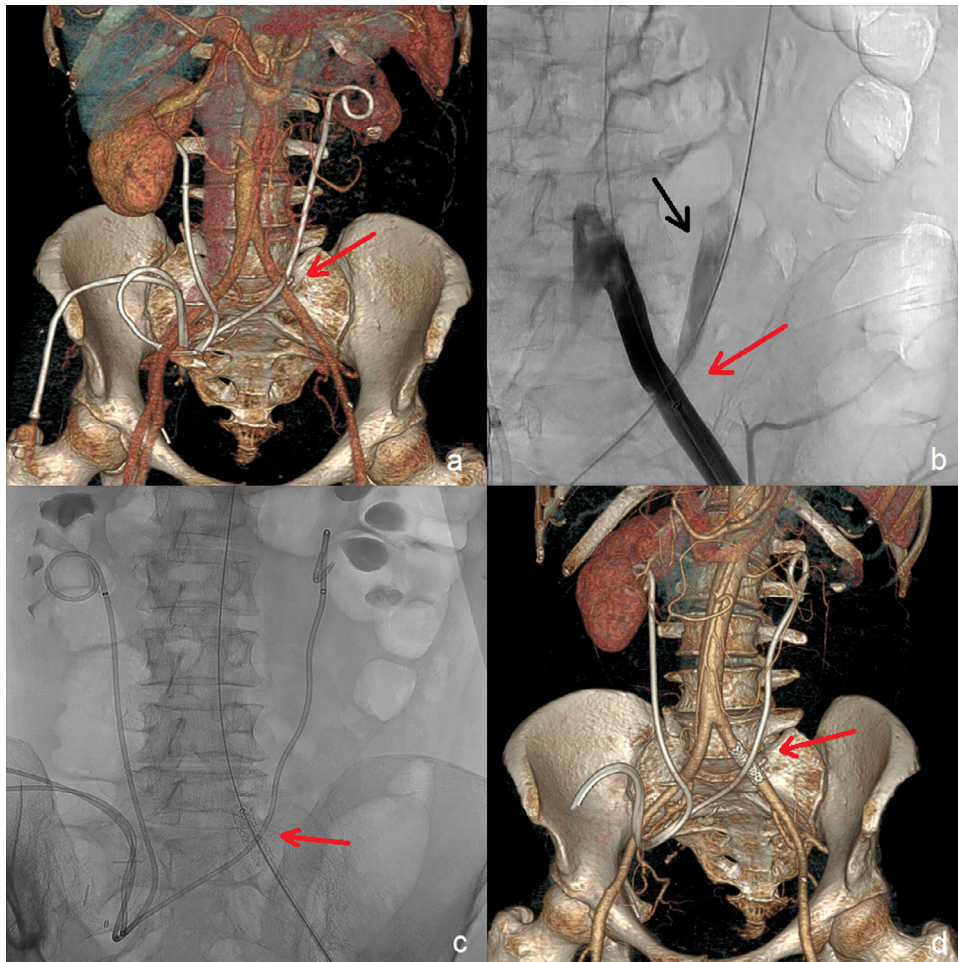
A 46-year-old woman with previous history of hysterectomy, cystectomy and radiotherapy with uretero-ileocutaneous fistula because of endometrial cancer. Patient carries bilateral ureteral stents. 3D CT reconstruction shows contact between left ureteral stent and left common iliac artery (a, red arrow). Patient referred to the emergency room for conspicuous bleeding from the stoma associated with pain and drop in blood pressure. Left common iliac Digital Subtraction Angiography (DSA) performed urgently after removal of the ipsilateral ureteral catheter; a safety guidewire is left in place: DSA demonstrates the simultaneous opacification of the ipsilateral ureter (b, black arrow) with contrast agent passing through the fistula created by the ureter stent (b, red arrow). Fluoroscopy shows a covered stent positioned to occlude the point of arterio-ureteral fistula (c, red arrow). Postprocedural 3D CT reconstruction demonstrates the correct positioning of the covered stent (d, red arrow). (Color version of figure is available online.)
